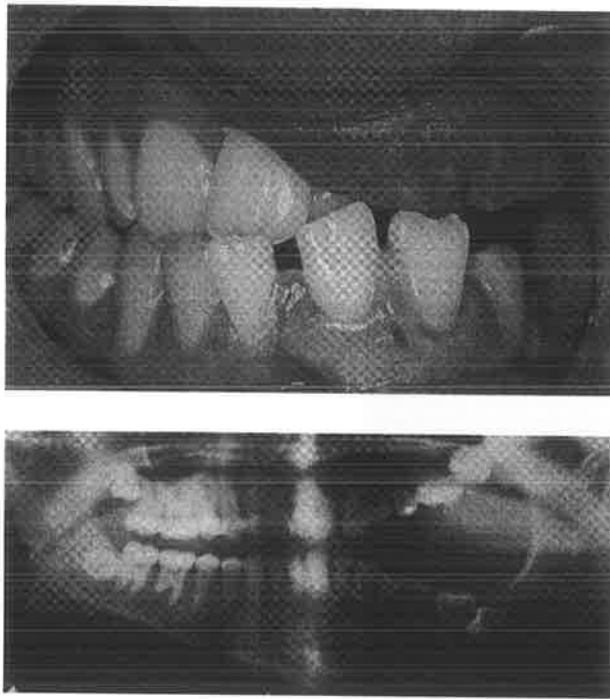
Occlusal view confirming the intraoral extension, with the corresponding skeletal changes in the maxilla and mandible manifest on the orthopantomogram.
